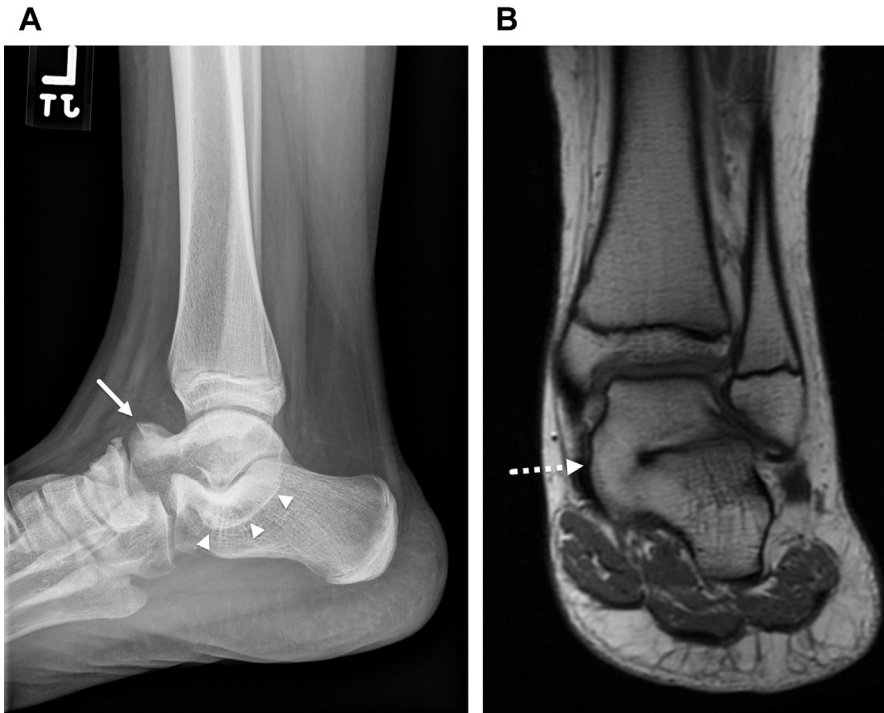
Talocalcaneal coalition in a 12-year-old girl with persistent left ankle pain and cramping. (A) Lateral radiograph shows dorsal beaking (*arrow*) of the talus and a continuous C-sign (*arrowheads*). (B) Coronal T1-weighted MR image confirms complete osseous coalition (*interrupted arrow*) between the talus and calcaneus.
